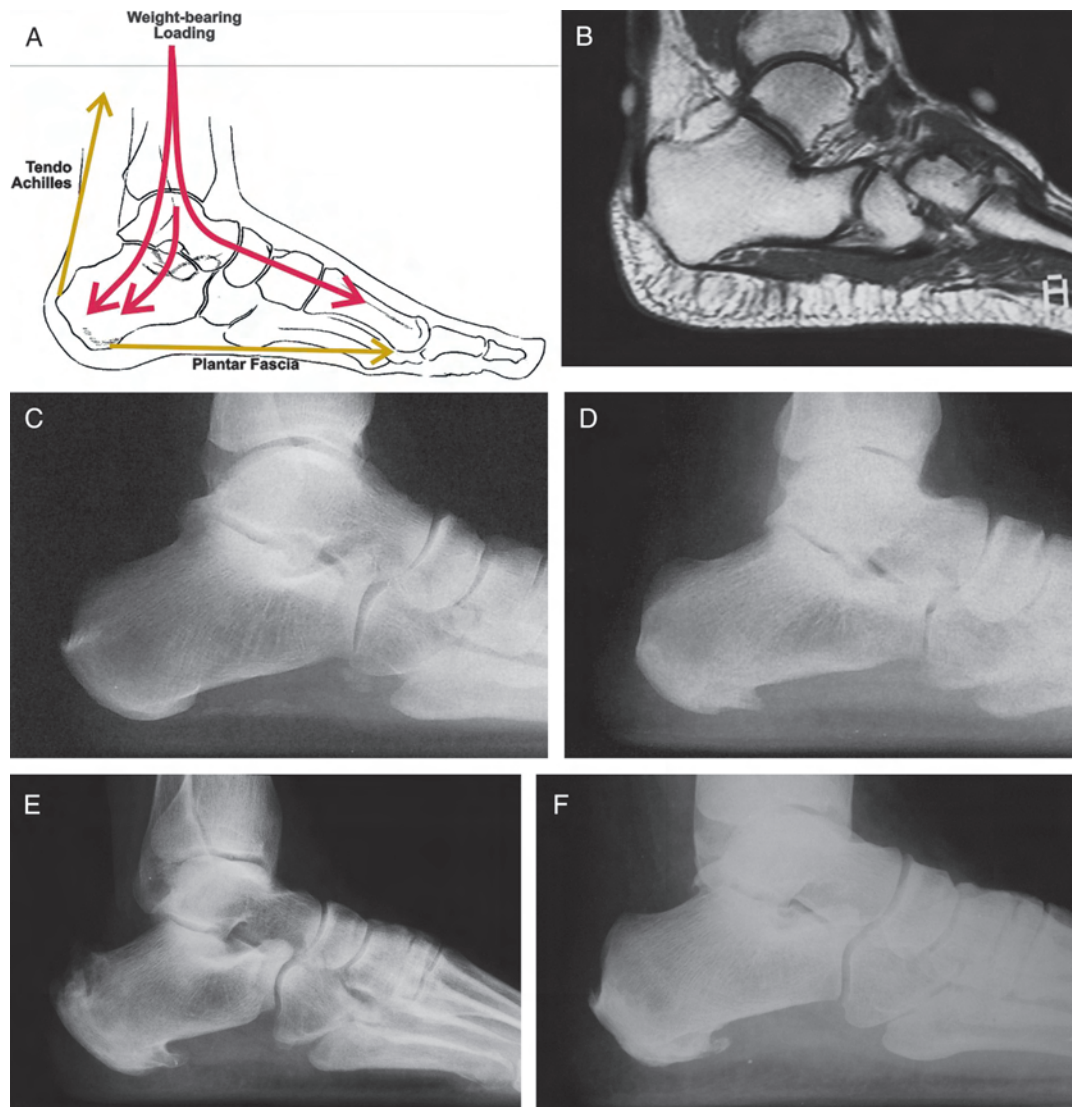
Plantar heel pain often is related to (A) loading of the calcaneus and the tensile attachment of the plantar fascia, as shown in this MRI scan (B). (C) The weight-bearing lateral radiograph may or may not show an inferior os calcis spur. (D, E) The spur or enthesophyte begins small and may become very large, or on occasion, (F) may even fracture.
